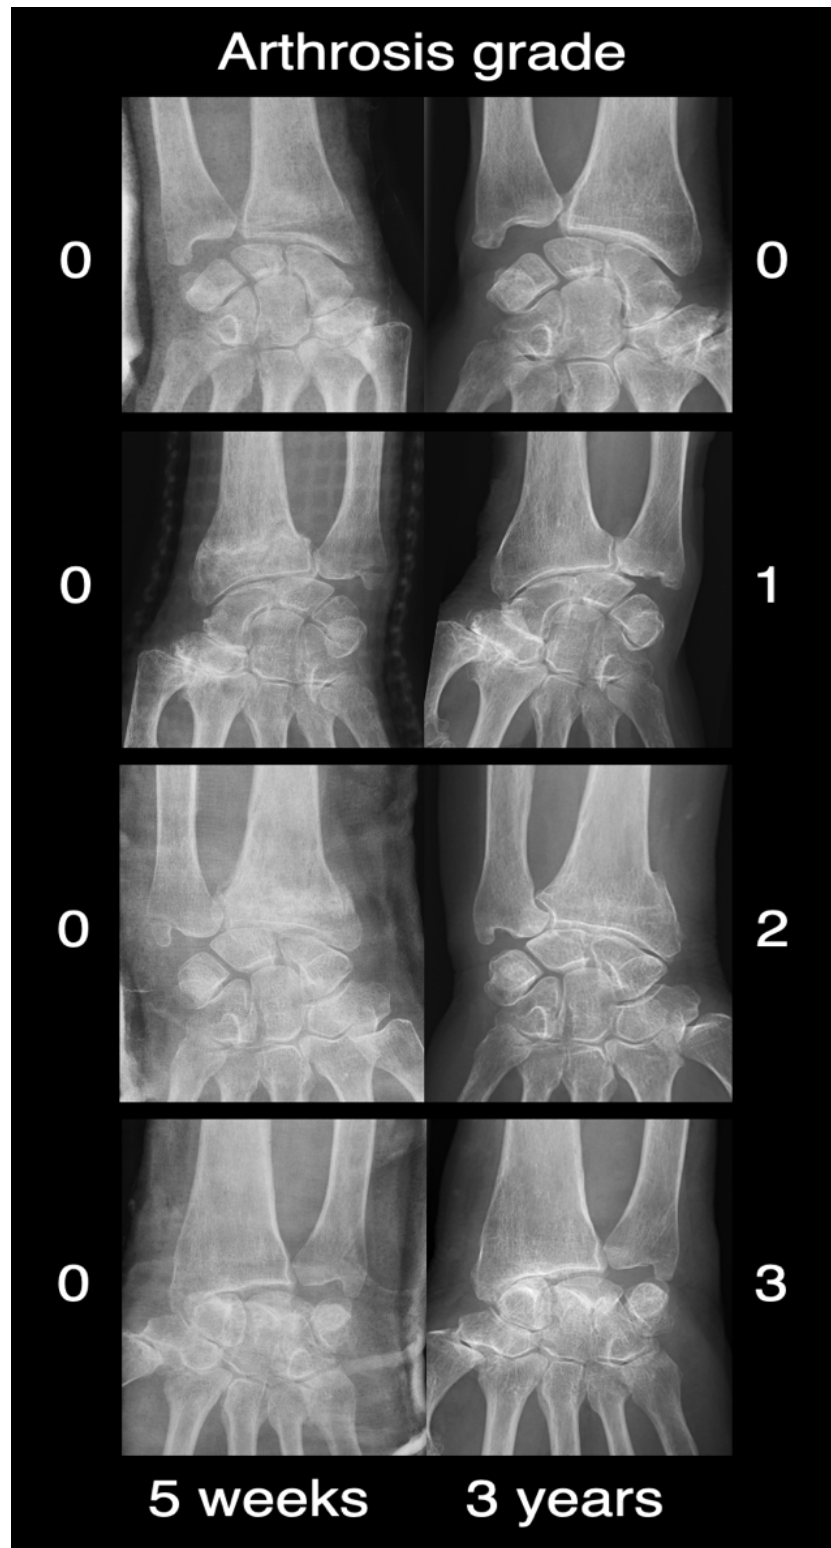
Examples of assessed anteroposterior radiographs with PA grades 0, 1, 2 and 3 after 5 weeks and a mean of 3.3 years after the injury.
